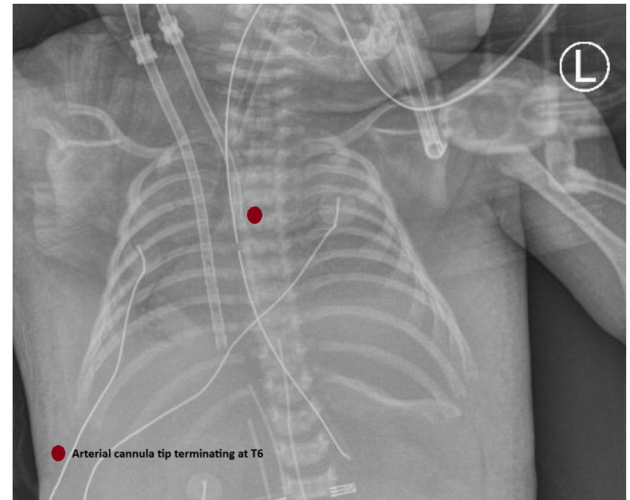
Chest radiograph, anterior-posterior projection, demonstrates the VA-ECMO cannula positions (red circles) with the arterial cannula tip terminated at T6, which was deeper than its location at insertion.
